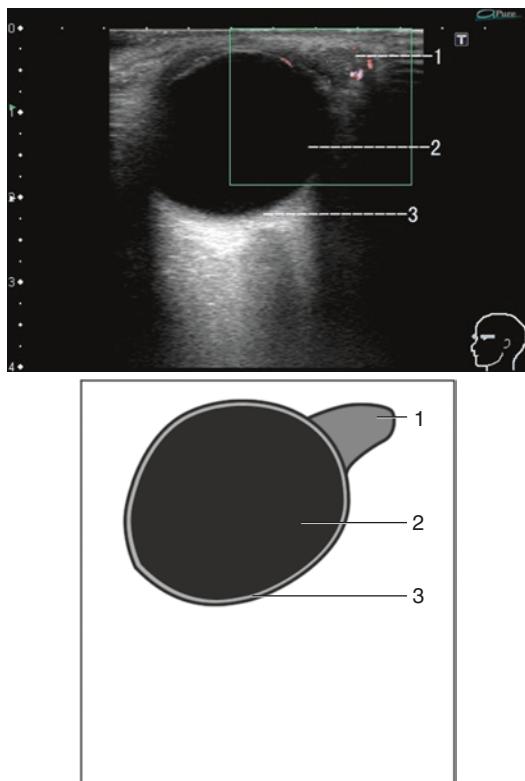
Sonogram of the normal lacrimal gland. Note: 1 lacrimal gland, 2 vitreous body, 3 eyeball
